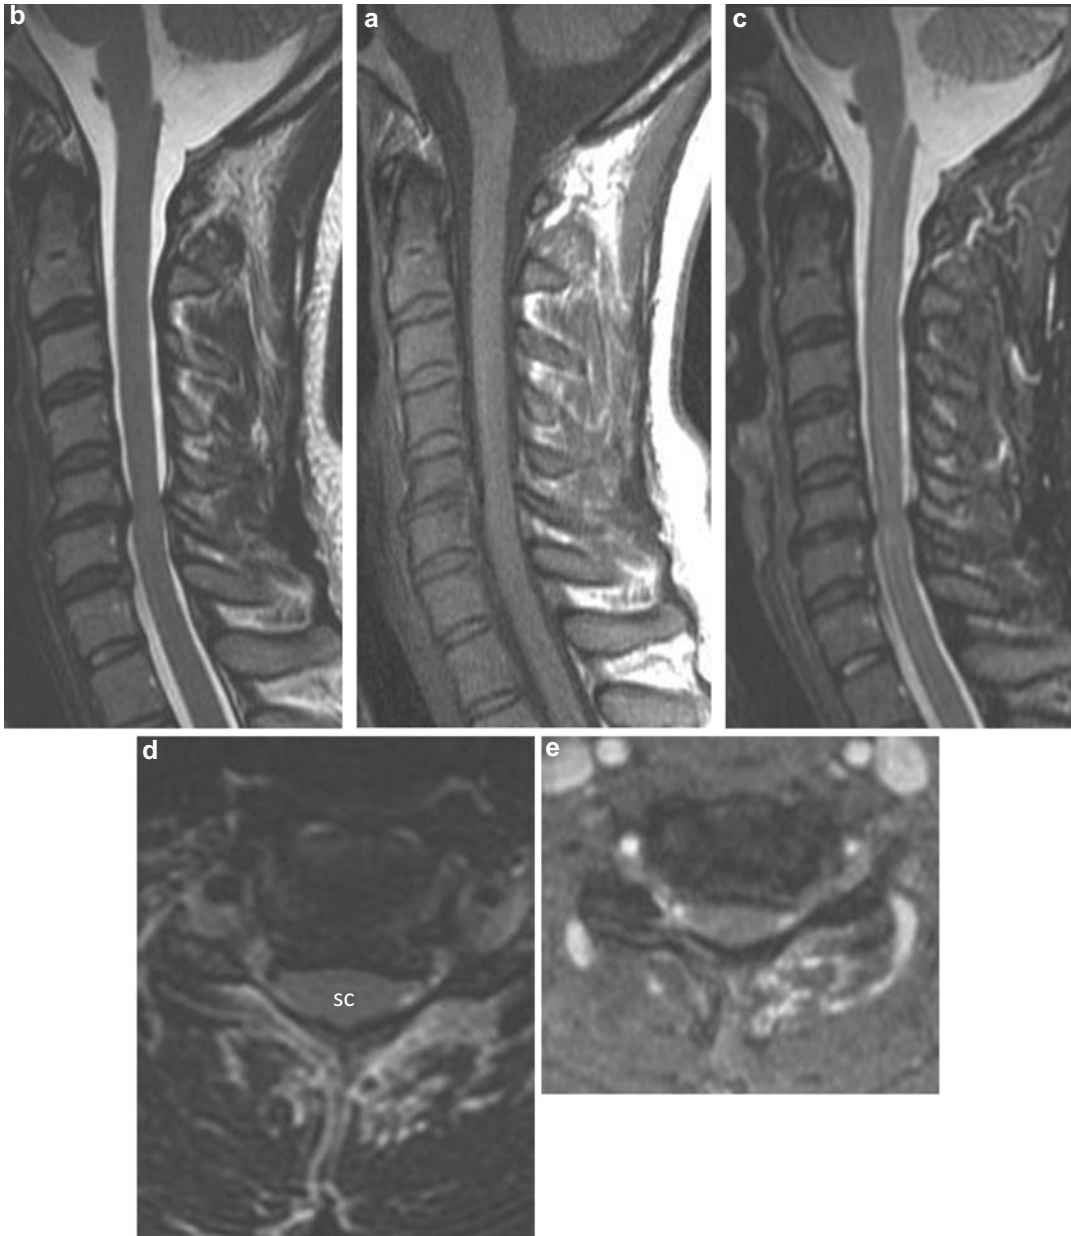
Representative MR images show disc osteophyte complex at C5-C6 causing moderate bilateral neuroforaminal narrowing and severe central canal stenosis (lack of hyperintense CSF around spinal cord). (a, b, c) Sagittal T1W, Sag T2W and SAG STIR images show C5-C6 disc space narrowing without spinal cord signal abnormality on the STIR or T2W sequences. (d) Axial T2W image shows severe central canal stenosis as noted by lack of hyperintense CSF around the spinal cord. (e) Axial T2 GRE image demonstrates moderate bilateral neuroforaminal narrowing
